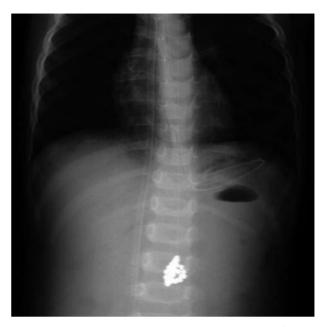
Abdominal x-ray shows multiple metallic foreign bodies in the median abdomen
